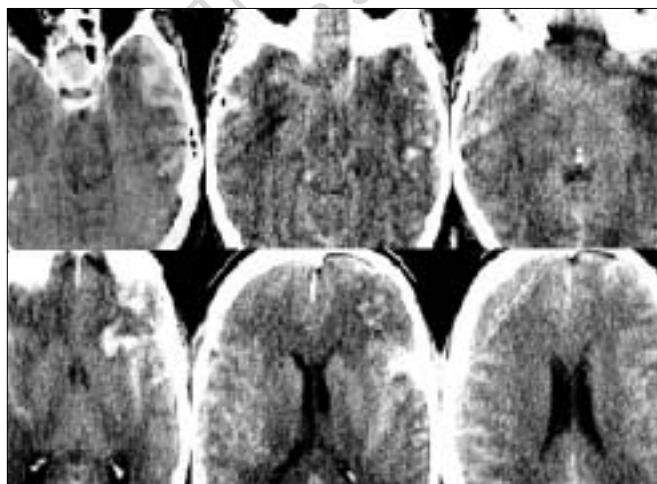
First CT scan of case 2 showing bilateral SAH involving fronto-temporo-parietal region and bilateral temporal contusions, more on left side
